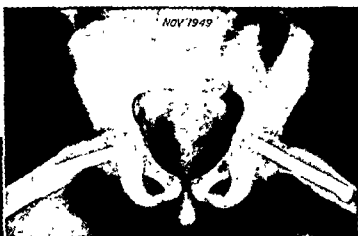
Early postoperative roentgenograms showing excellent fixation and position. (Left) Anteroposterior view. (Right) Lateral view.
